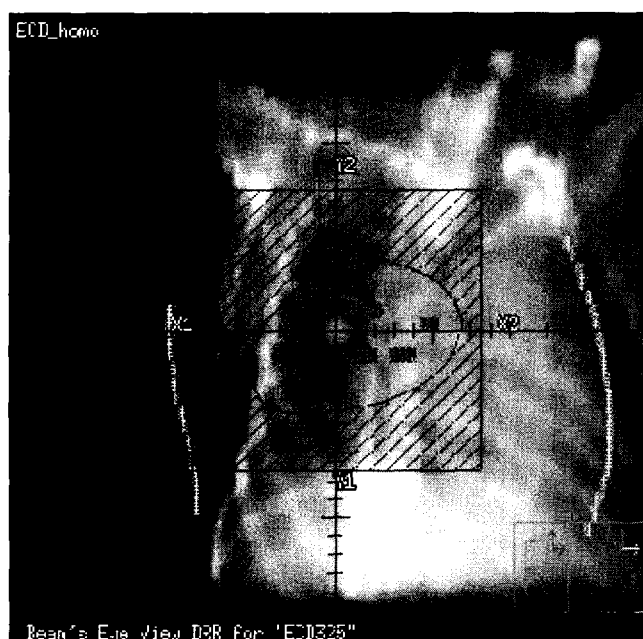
Irregular electron block on CT image of a breast cancer patient.
